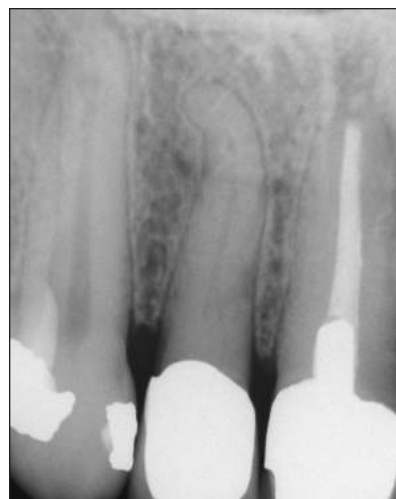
A radiograph taken 7 1/2 years later shows little evidence of the original resorption.
